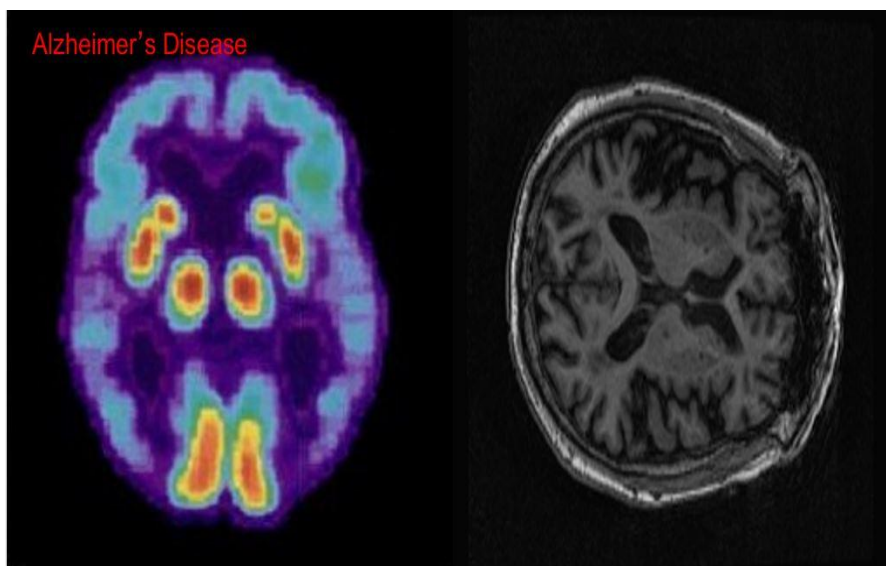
MRI and PET image having Alzheimer's disease is correctly classified under the class of Alzheimer's disease
